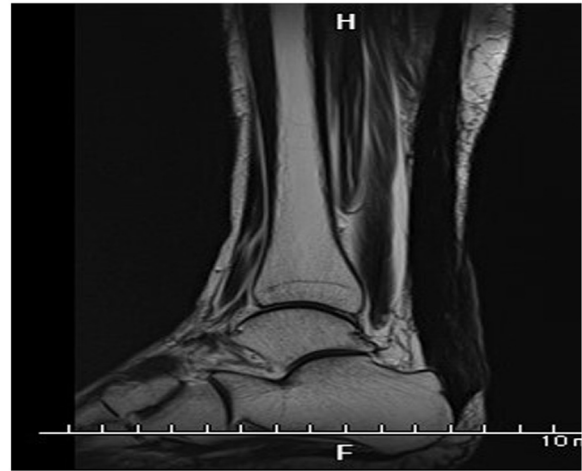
T2 weighted sagittal Magnetic Resonance Image showing a well-bridged Achilles tendon with normal signal intensity at three months after the surgical debridement.
